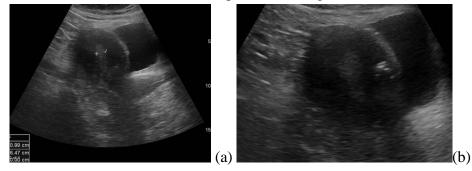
(a) Ultrasound images showing thick echogenic endometrium (9mm) and (b) calcified small uterine fibroid related to the anterior wall.
